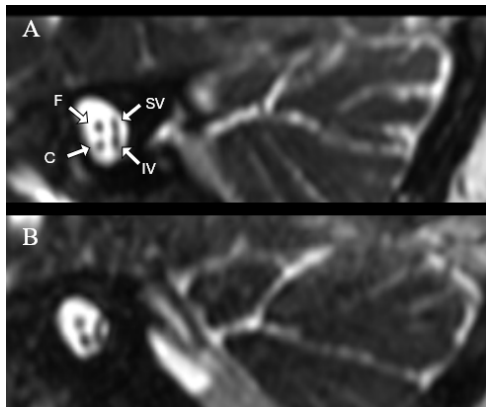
Oblique sagittal MRI of Patient II-2. (A) The distal slice shows the facial (F), superior vestibular (SV), inferior vestibular (IV) and cochlear (C) nerves of the right ear. (B) The distal slice shows the F, SV, IV, and C nerves of the left ear.
